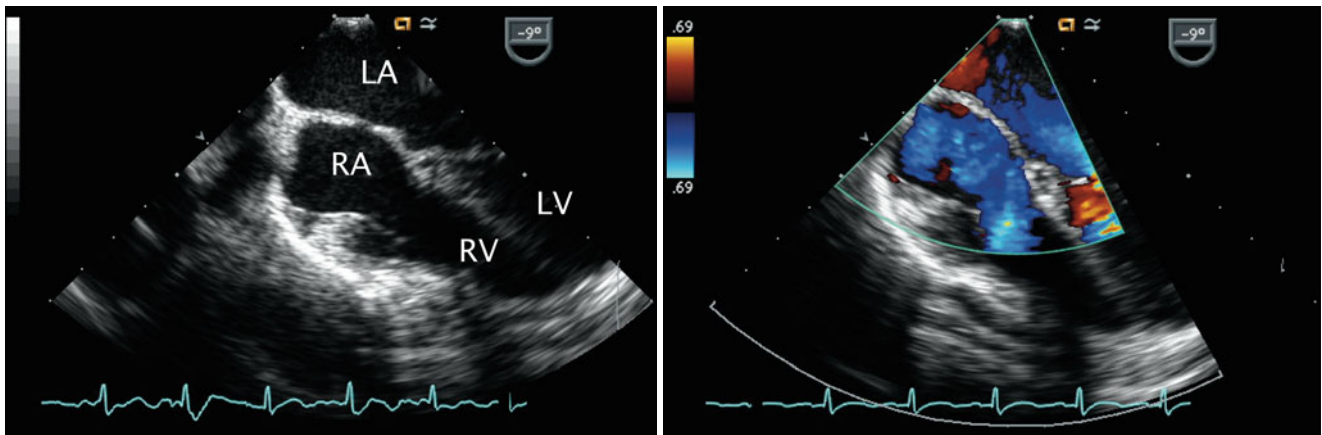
Left panel:* Image obtained by turning of the imaging probe from the mid esophageal four chamber view clockwise to visualize right-sided structures. *Right panel:* Color Doppler demonstrates an
